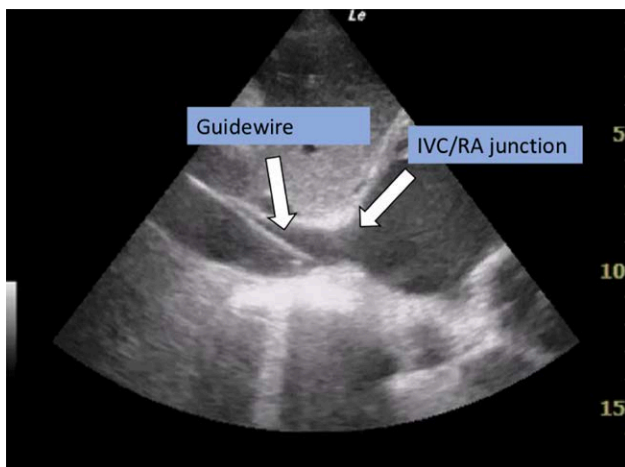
Cardiac echocardiography in the subcostal view demonstrating guidewire position in the IVC/RA junction. IVC, inferior vena cava; RA, right atrium.
